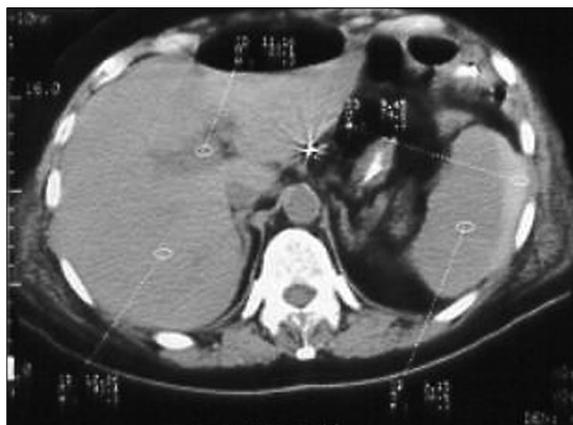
Postoperative precontrast CT scan. Status post gastrectomy. Hyperdense zone next to the spleen looking as subcapsular hematoma. Gas collection in front of the liver.
